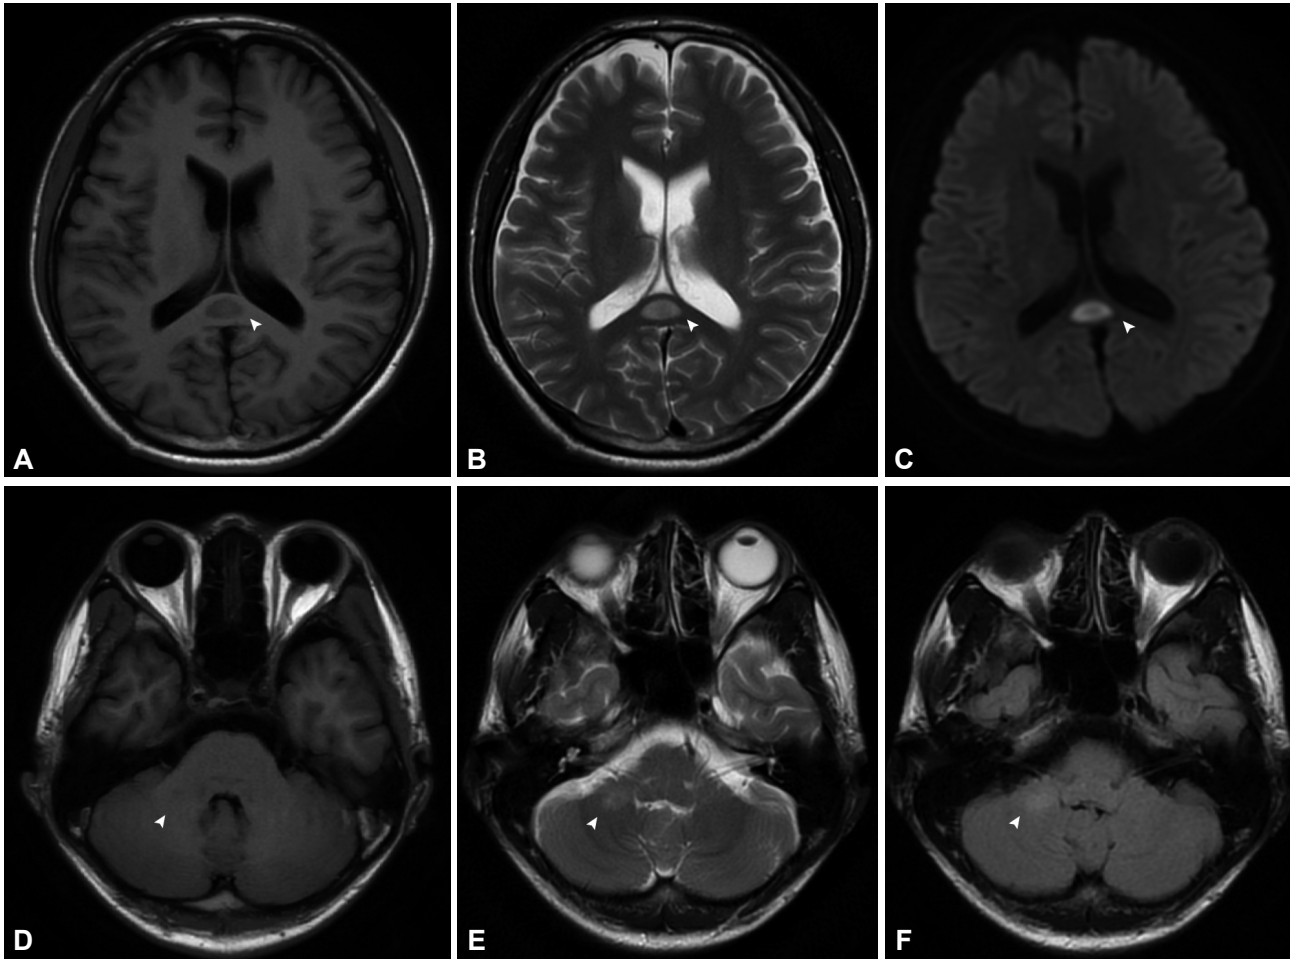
MRI performed on August 9 showed slightly long T1-weighted (A), and T2-weighted (B) values for the splenium of the corpus callosum (arrowheads) with a high diffusion-weighted-imaging signal (C), and equal T1 signal (D), slightly high T2 (E), and T2 Flair values (F) for the right middle cerebellar peduncle (arrowheads).
